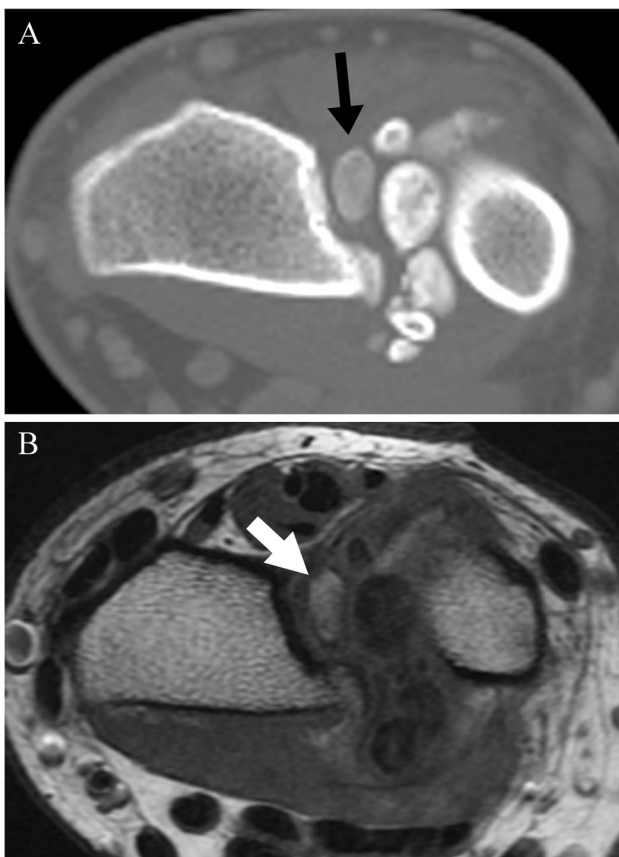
A 25-year-old man with synovial chondromatosis. (A) Axial CT image shows calcified nodules. (B) Axial T1-weighted image shows high T1 signal (arrow) consistent with marrow fat in the nodule
